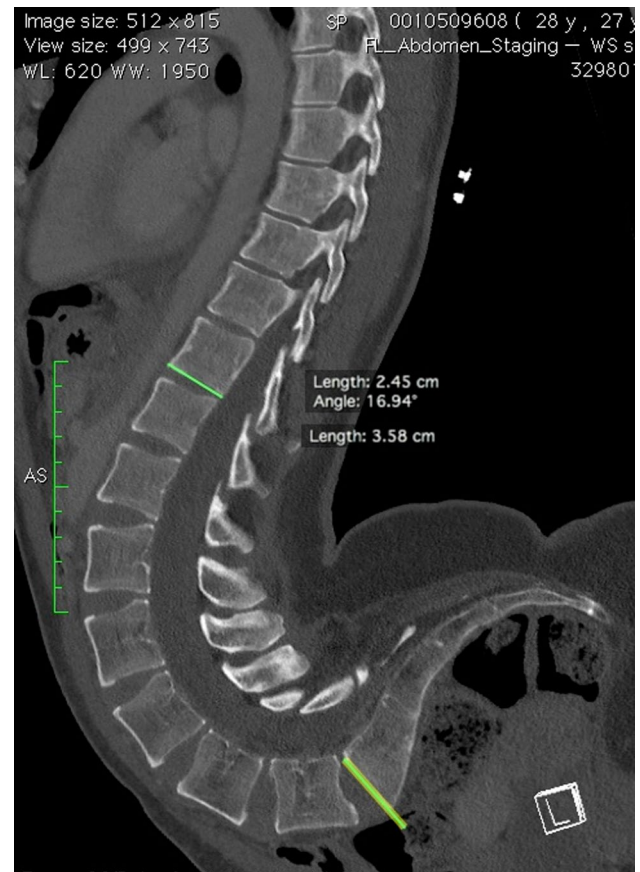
Sagittal reconstruction from a CT scan acquired a few weeks prior to surgery. The lordosis angle now measures above 160°
